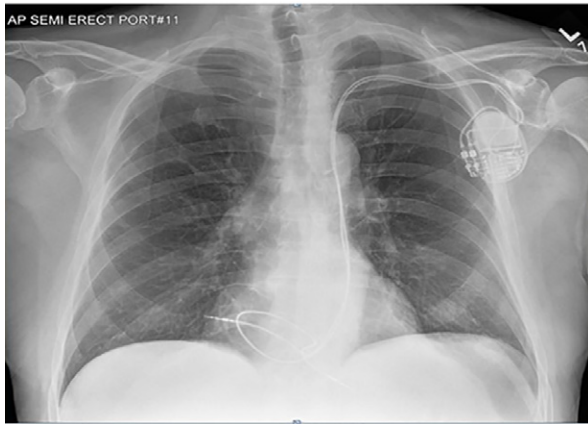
Chest radiograph shows an unusual course of the dual-chamber pacemaker leads.
